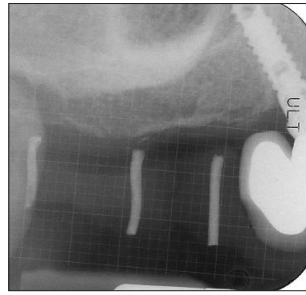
Periapical radiograph of the site 13 implant, which is distally angulated into site 14. A grid shows lack of bone height at sites 15 and 16.
